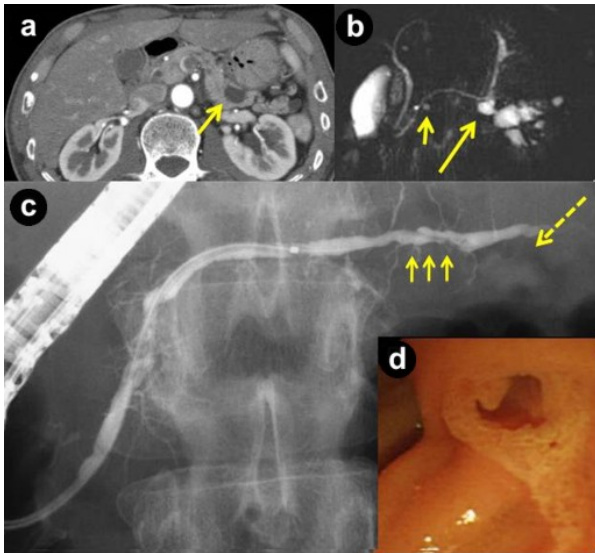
a. Computed tomogram showing a low density mass in the tail of the pancreas, the size of which had slightly increased to 15 mm in diameter (arrow). b. Magnetic resonance cholangio-pancreatogram demonstrating two small cystic lesions; 10mm in diameter in the pancreatic tail (long arrow) and 5mm in the pancreatic head (short arrow). c. ERCP showing a cystic lesion measuring 10 mm in the tail of the pancreas (arrow with broken line), and stenotic lesions in the main duct of the pancreatic body (arrows). d. Endoscopic photograph of the dilated orifice of the duodenal papilla with mucin excretion.
